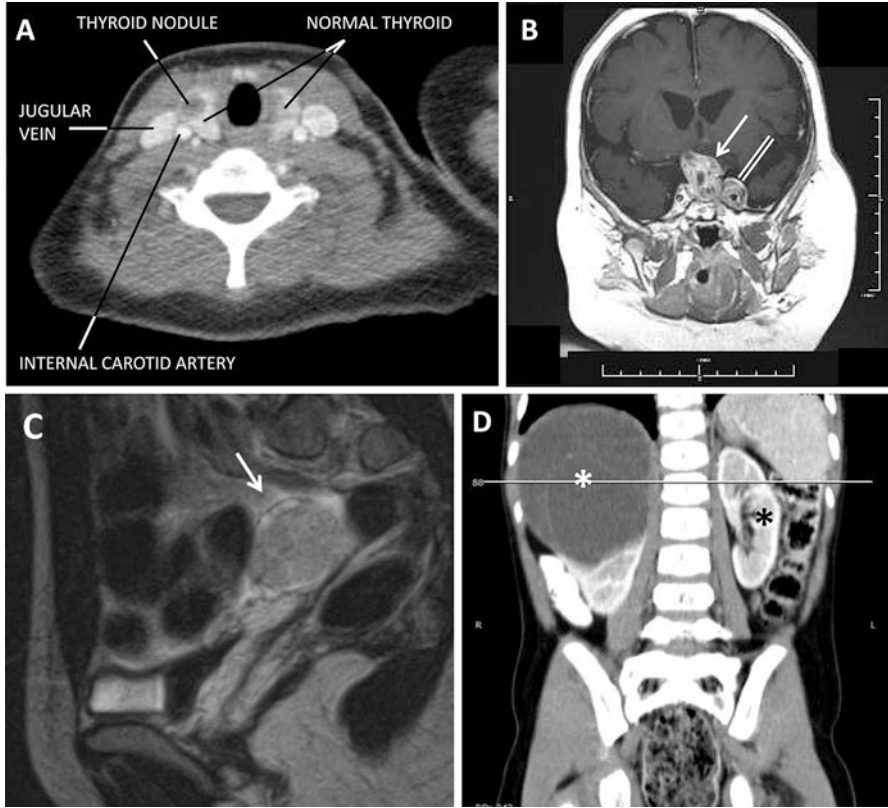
Radiology images. (a) Axial cervical region contrast-enhanced CT image of multinodular goiter. (b) Coronal gadolinium-enhanced magnetic resonance image of pituitary blastoma (white arrow) with left cavernous sinus involvement (double white line). (c) Sagittal pelvic region CT image showing ovarian Sertoli-Leydig cell tumor (arrow). (d) Coronal contrast-enhanced abdominal CT image showing multilocular fluid-filled mass pathologically proven to be cystic nephroma in the upper pole of right kidney (white asterisk) above residual normal right lower pole; normal left kidney indicated by black asterisk. (Images courtesy of the patient [A], Marek Niedziela, M.D. Ph.D. [C], and Yves Heloury, M.D. FRACS [D])
